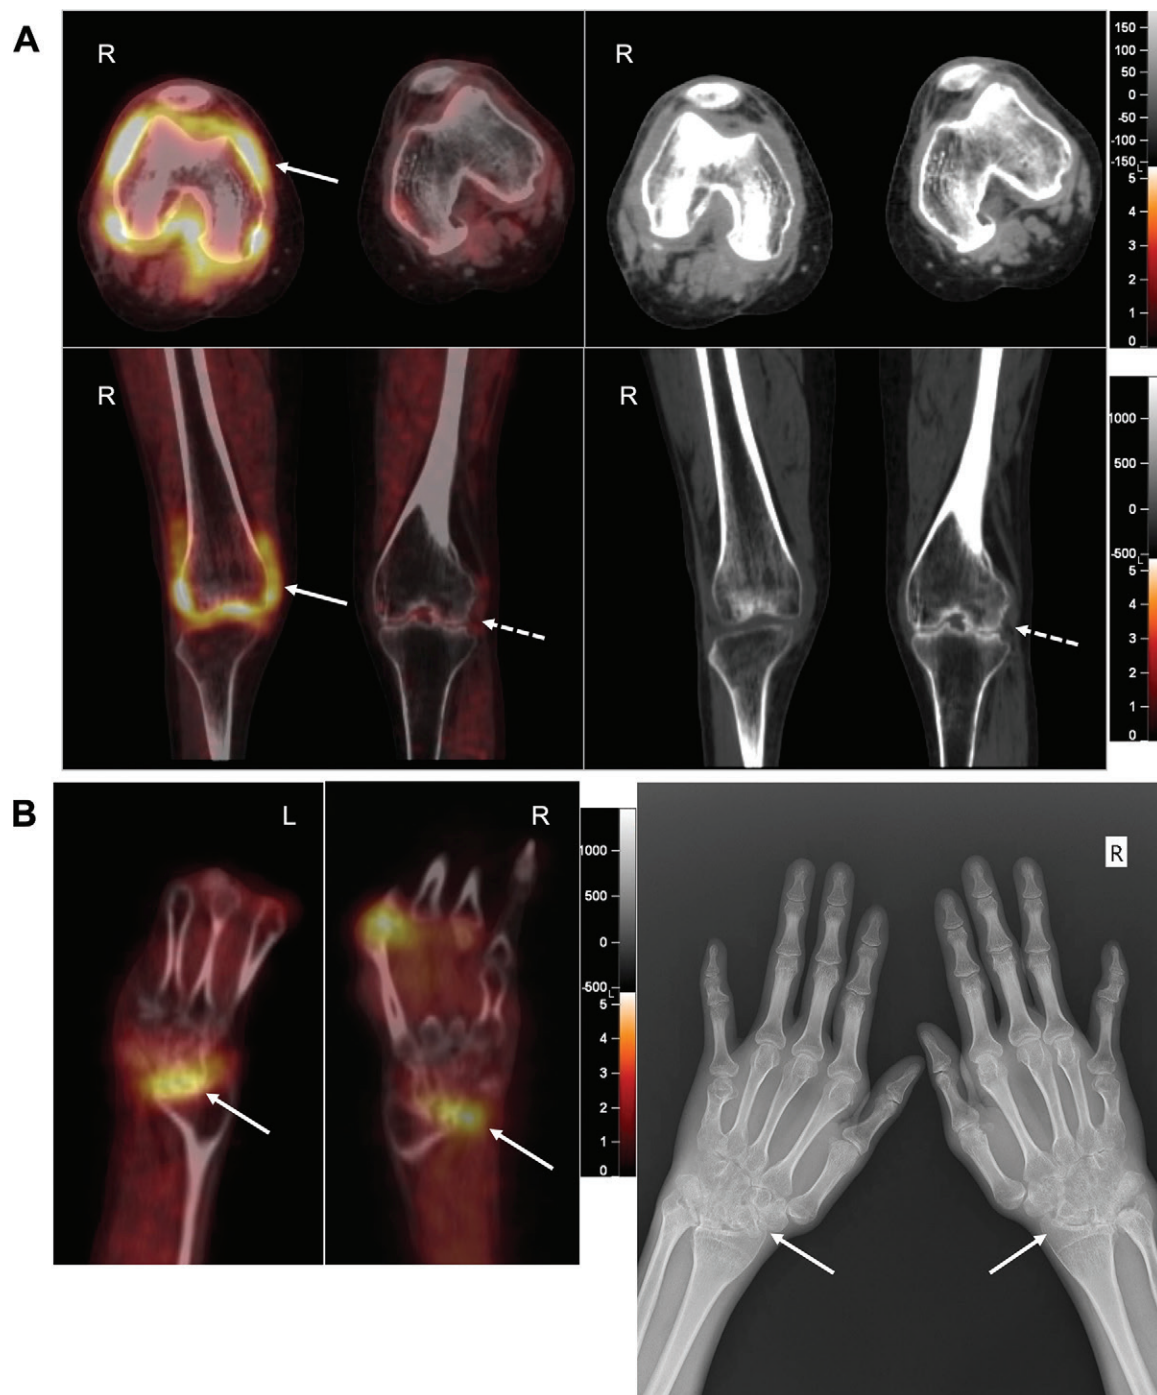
Fusion images show gallium 68 (^{68}Ga)-labeled fibroblast activation protein inhibitor (FAPI) uptake in the synovium of affected joints. (A) Axial (top row) and coronal (bottom row) ^{68}Ga -FAPI fusion (left side) and co-registered CT images (right side) in a 65-year-old woman with a 31-year history of rheumatoid arthritis. Intense ^{68}Ga -FAPI activity is in the right knee (arrows, also a tender joint at physical examination) and the synovium of the right knee is also thickened. Joint space narrowing and bone destruction is in the left knee (dashed arrows), but neither ^{68}Ga -FAPI or fluorine 18-labeled fluorodeoxyglucose uptake is observed in the joint, representing osteoarthritis without a substantial inflammatory component. The left knee is not clinically tender or swollen. (B) ^{68}Ga -FAPI fusion images (left images) and radiograph (right image) of the hands and wrists (^{68}Ga -FAPI PET/CT performed 6 days later than radiography) in a 25-year-old woman with a 13-year history of rheumatoid arthritis. There is increased ^{68}Ga -FAPI activity in both wrists (arrows, left), and joint space narrowing, bone destruction, and joint deformity is observed (arrows, right).
